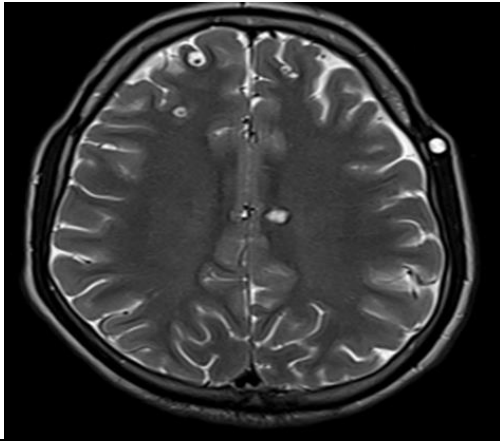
MRI Brain: Axial T2W: Hypertintense signal in scalp.
